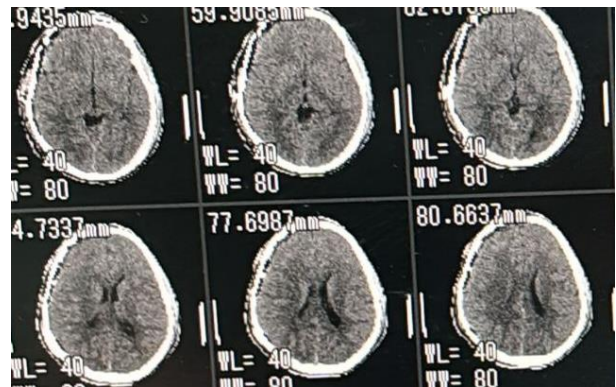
Post operative non contrast CT head showing near total evacuation of both hematomas with resolution of mass effect.
